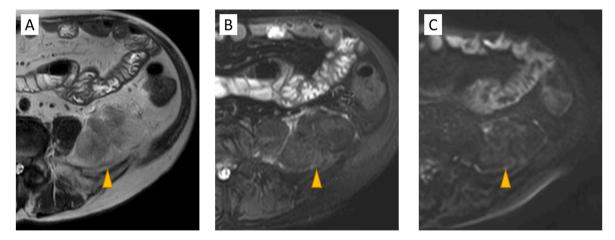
T2-weighted (A), fat suppressed T2-weighted (B), and diffusion-weighted (C) magnetic resonance imaging reveal that the tumor is composed of fat component with relatively low cellular density.
